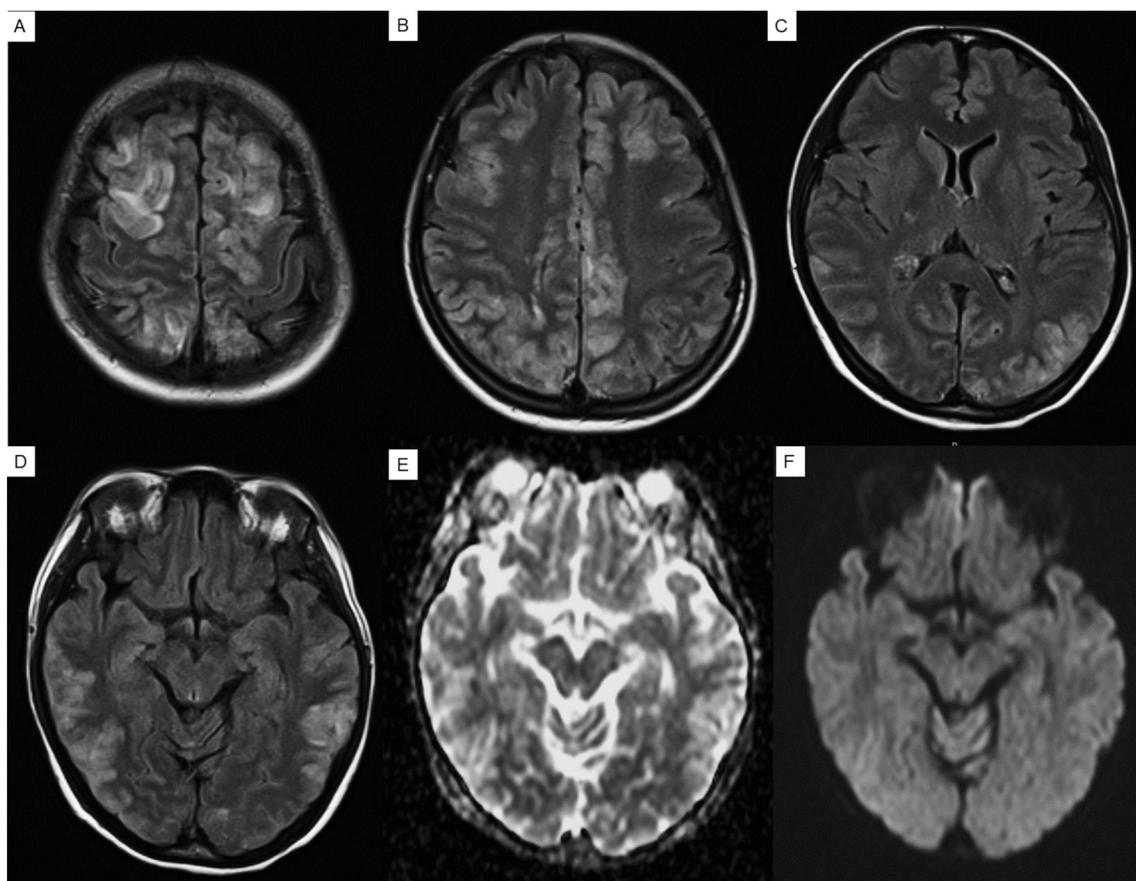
Typical MRI findings in PRES. A 21-year-old woman with adult Still's disease on cyclosporine presented with seizures. Axial T2 fluid-attenuated inversion recovery sequences show predominantly cortical and subcortical white matter bilaterally in the frontal lobes (A), watershed regions (B), occipital regions (C), and posterior parietal and temporal regions (D). Apparent diffusion coefficient mapping demonstrates cortical/subcortical vasogenic edema with hyperintense signal lesions (E), but these lesions are not recognized in diffusion-weighted images (F).
